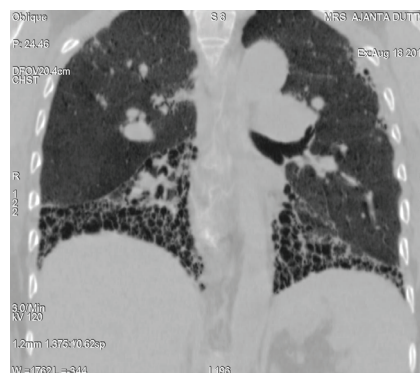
HRCT thorax on 18.08.2017 suggestive of ILD with prominent bi-basal honeycombing and pulmonary hypertension
